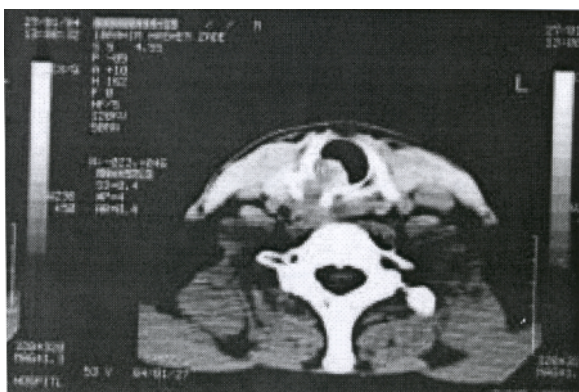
Preoperative CT scanning
